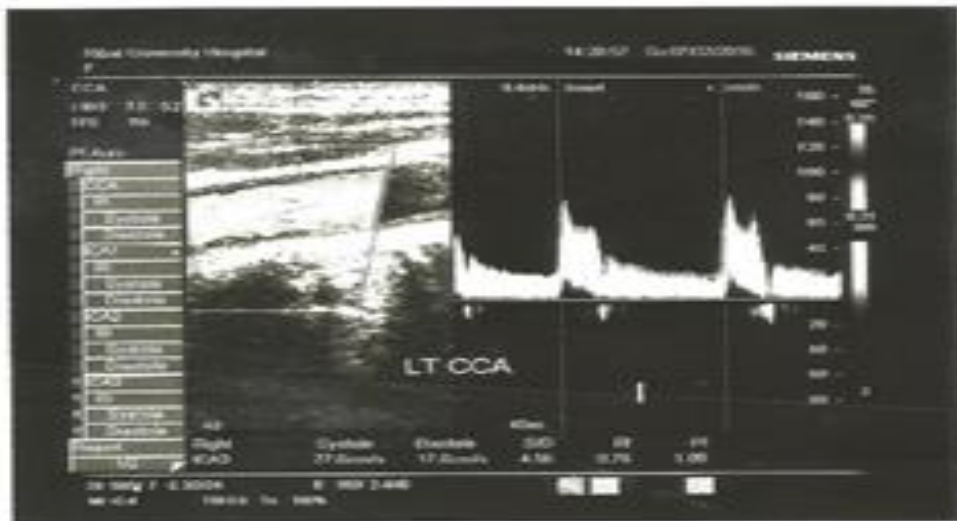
Lt ICA-male- 68 years diabetic patient with normal Doppler parameters.
